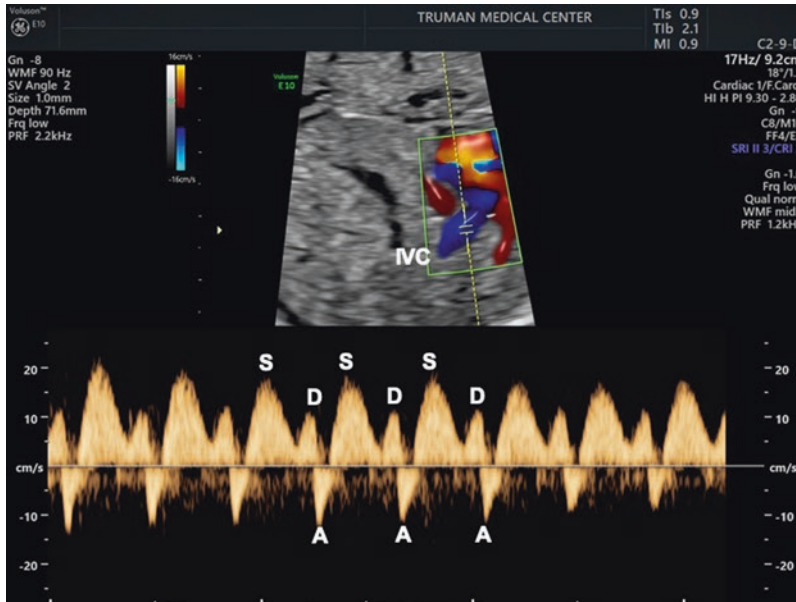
Color and spectral Doppler of the inferior vena cava (IVC). Spectral Doppler interrogation of the inferior vena caval flow. Right: Color flow imaging of the inferior vena cava and placement of the Doppler sample volume. Left: Inferior vena caval Doppler waveforms. It is noted
